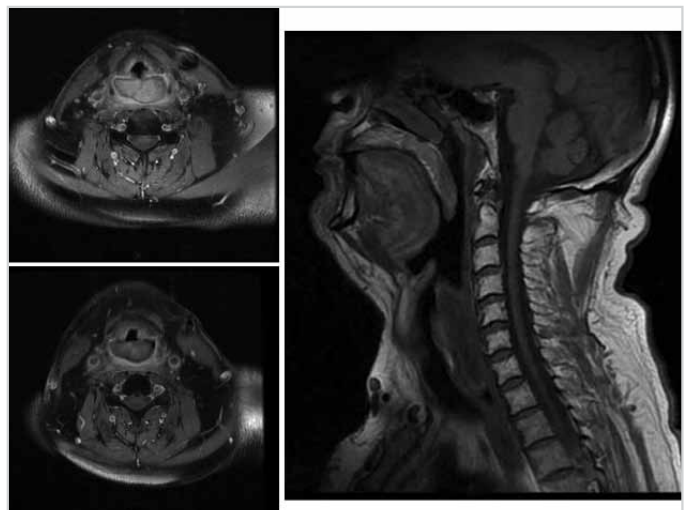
MRI images of patient in eighth year with the vegetative tumor on the hypopharynx
